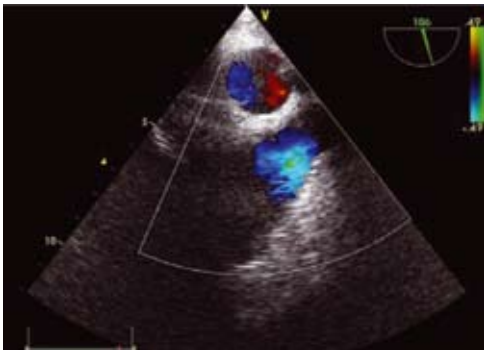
SVC flow by color Doppler study after clot removed
